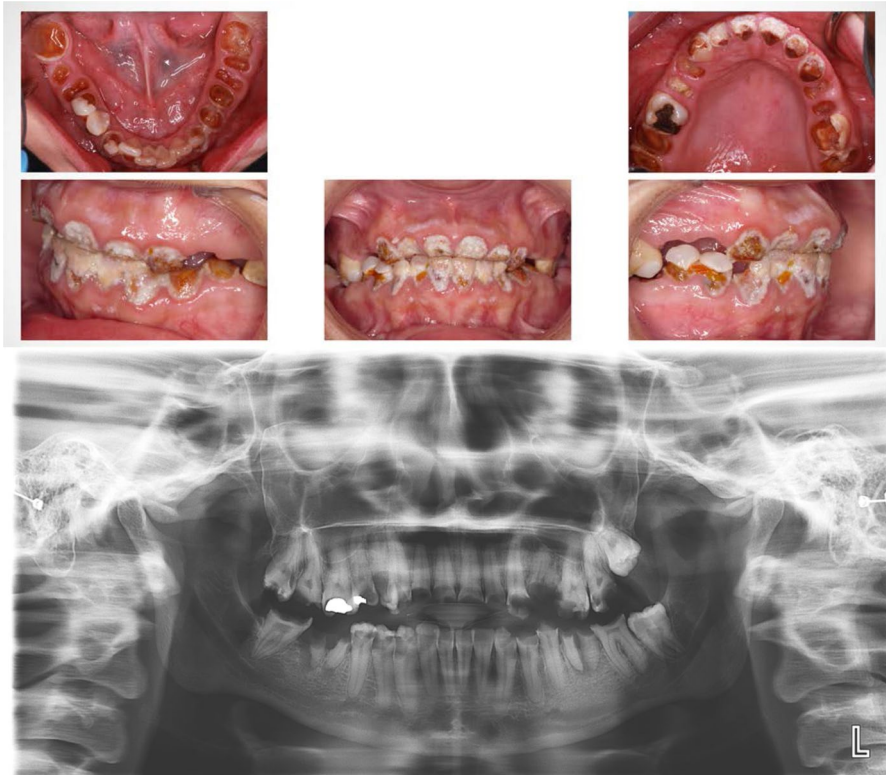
Clinical photos and a panoramic radiograph of a 27-year-old patient with a history of methamphetamine use for a number of years. Prevention and early intervention are necessary in SUD to prevent irreversible damage to oral structures as seen in the photos below
